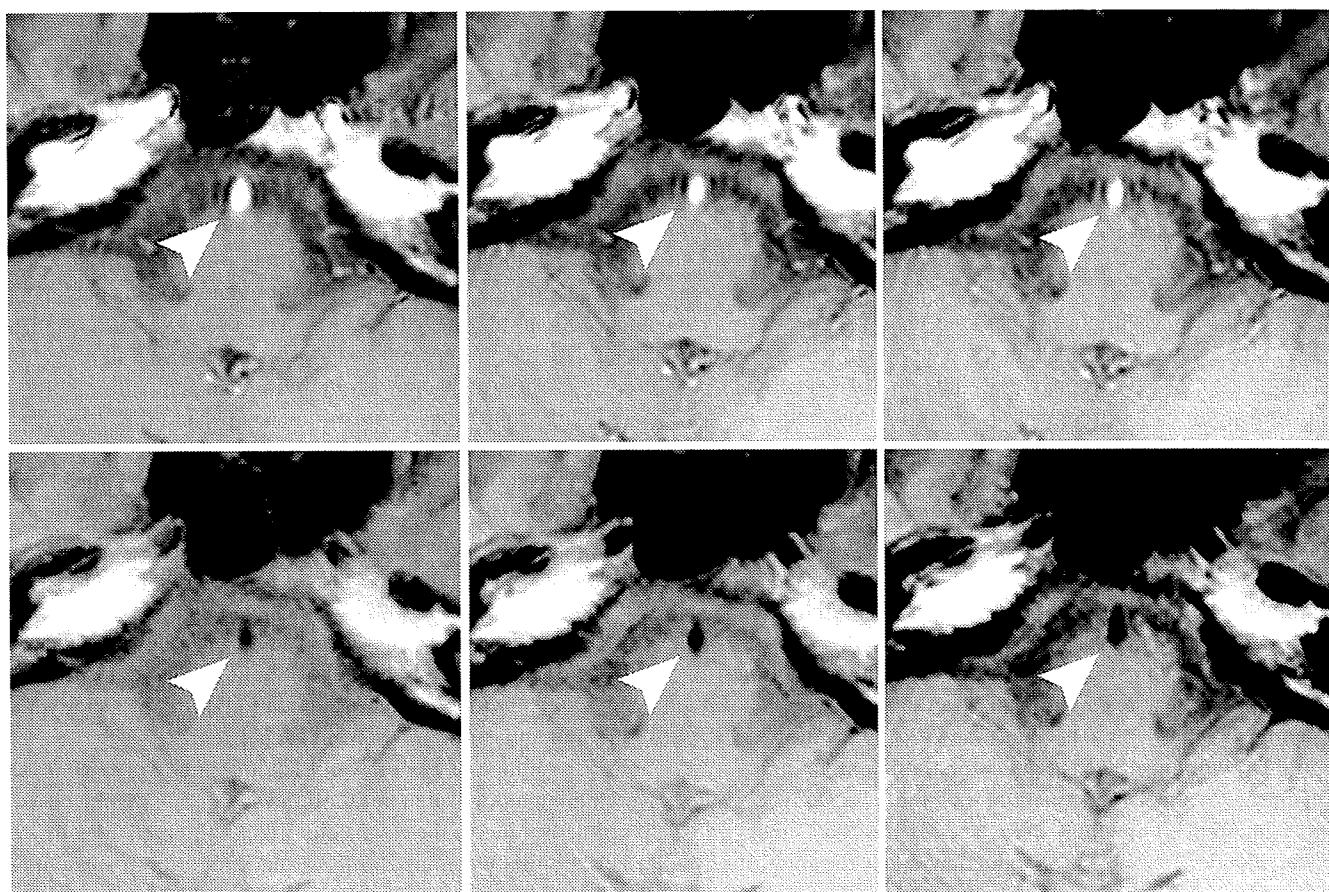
Spin-echo T1-weighted gapless multi-slice imaging at 3 T without presaturation pulse (PP) (*upper row*) and with PP (*lower row*) at the level of the pons. From left to right, sequential imaging, 100% interleaved imaging and 200% interleaved imaging are displayed. Basilar intra-arterial signals were sufficiently suppressed on imaging with PP (*lower row*).
